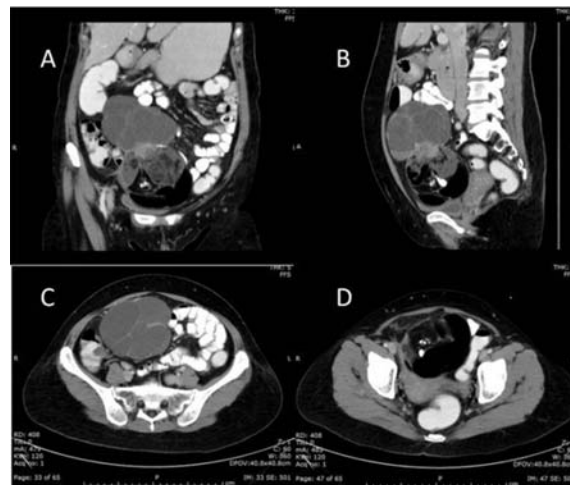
Abdominal CT scan of this patient demonstrated a well-defined lobulated contour solid and cystic mass with containing multiple fat and calcific components at pelvic cavity upward to umbilical region. Cystic portion (upper portion) showed multiple enhancing septation and solid nodules. Lower portion of mass showed solid cystic, fat and calcification components. A) Coronal plane. B) Axial plane of lower pelvis. C) Cross section plane of mass at upper portion. D) Cross section plane of mass at lower portion.
